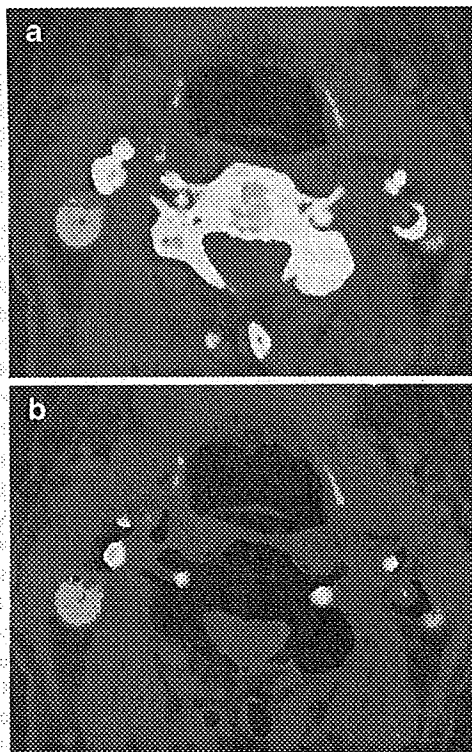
a Combined image generated from two datasets obtained at different tube voltage. b Dual-energy CT image of a carotid artery eliminated hard plaques with application of DE hard plaque removal. The pixels detected as bone or calcifications are displayed with a CT number of $-1,000$ HU on the DE hard plaque removal CT image
